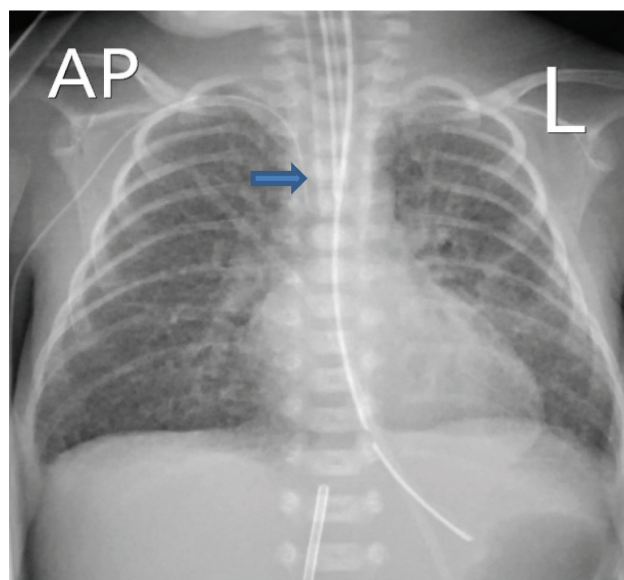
PICC line—optimal position. Chest X-ray showing right PICC line in SVC—0.5 cm away from the cardiac silhouette an optimal position.
